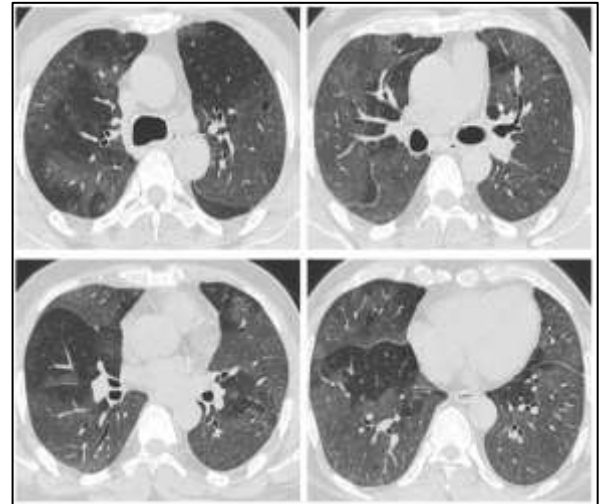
Axial CT images in lung window in a 70-year-old male. Diffuse and confluent GGOs are noted throughout bilateral lung fields involving all 5 lobes. CT severity score –24/25. This patient had elevated levels of TLC, SGOT, SGPT, CRP, d-dimer, S. Ferritin, IL-6, and LDH, and a reduced percentage of lymphocytes in DLC.
